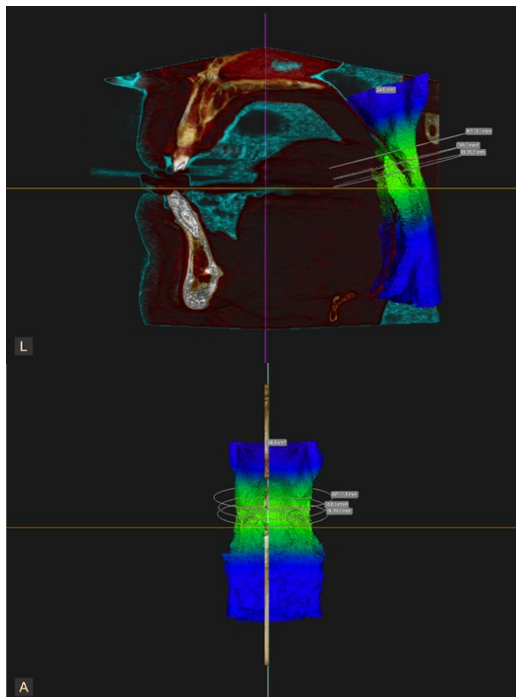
Pre-treatment CBCT Upper Airway Imaging results: minimum AP = 11.1 mm, minimum LAT = 29.7 mm, volume = 24.0 cm³, minimum area = 168.1 mm².
